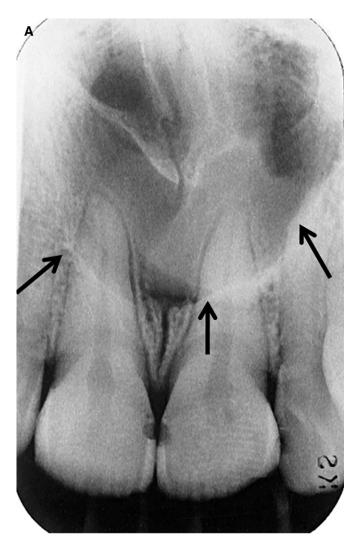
(A) Periapical film, showing the typical location of a nasopalatine cyst (arrows) centered on the incisive canal. (From Oral Radiology. 5th ed. White and Pharoah, Mosby, 2004, with permission.) (B) An axial computed tomography image of a nasopalatine cyst.
